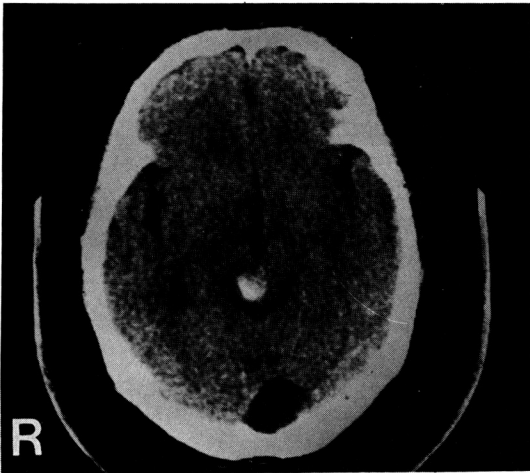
CT demonstrates an area of hemorrhage in the dorsal midbrain lateralized to the right.
